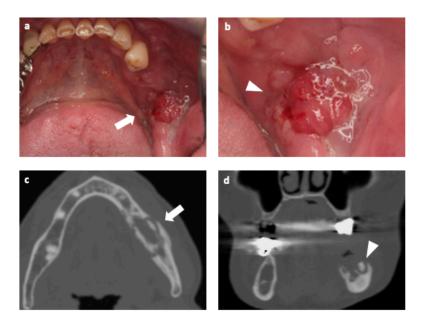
Stage 2 (Diffuse MRONJ): Panel a: clinical view showing hyperaemic and swollen gingiva of the alveolar socket filled with granulation tissue (white arrow). Panel b: close-up view of the lesion (white arrow-head). Panel c and d: axial and coronal CT reconstructions show bone marrow sclerosis that reaches the basal bone; bone sequestration and periosteal reaction (white arrow and white arrow-head, respectively).
